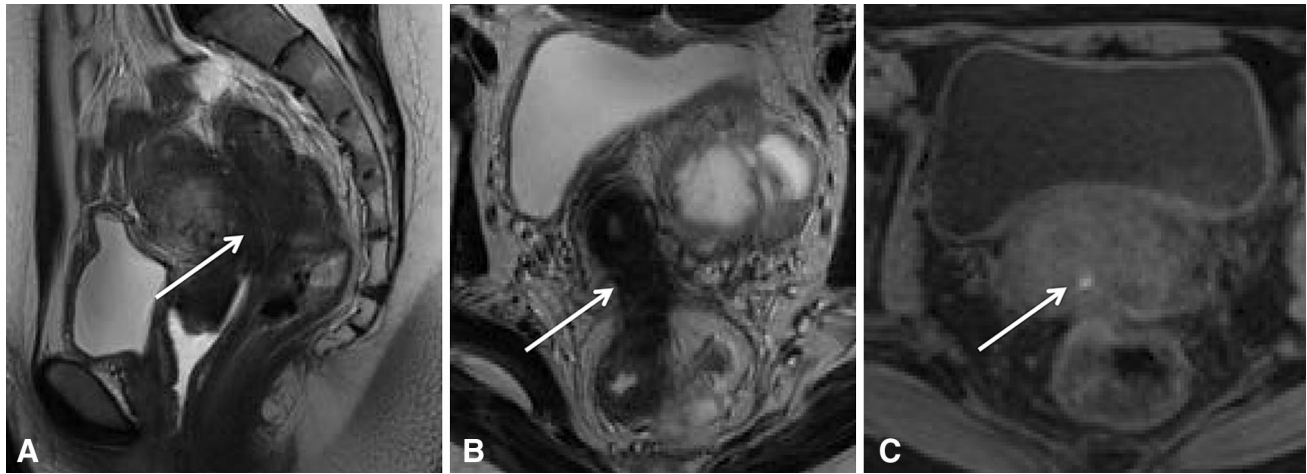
Biopsy proven invasive endometriosis. A Sagittal T2-weighted image shows extensive fibrosis (arrow), which obliterates the rectovaginal septum and invades the anterior rectal
